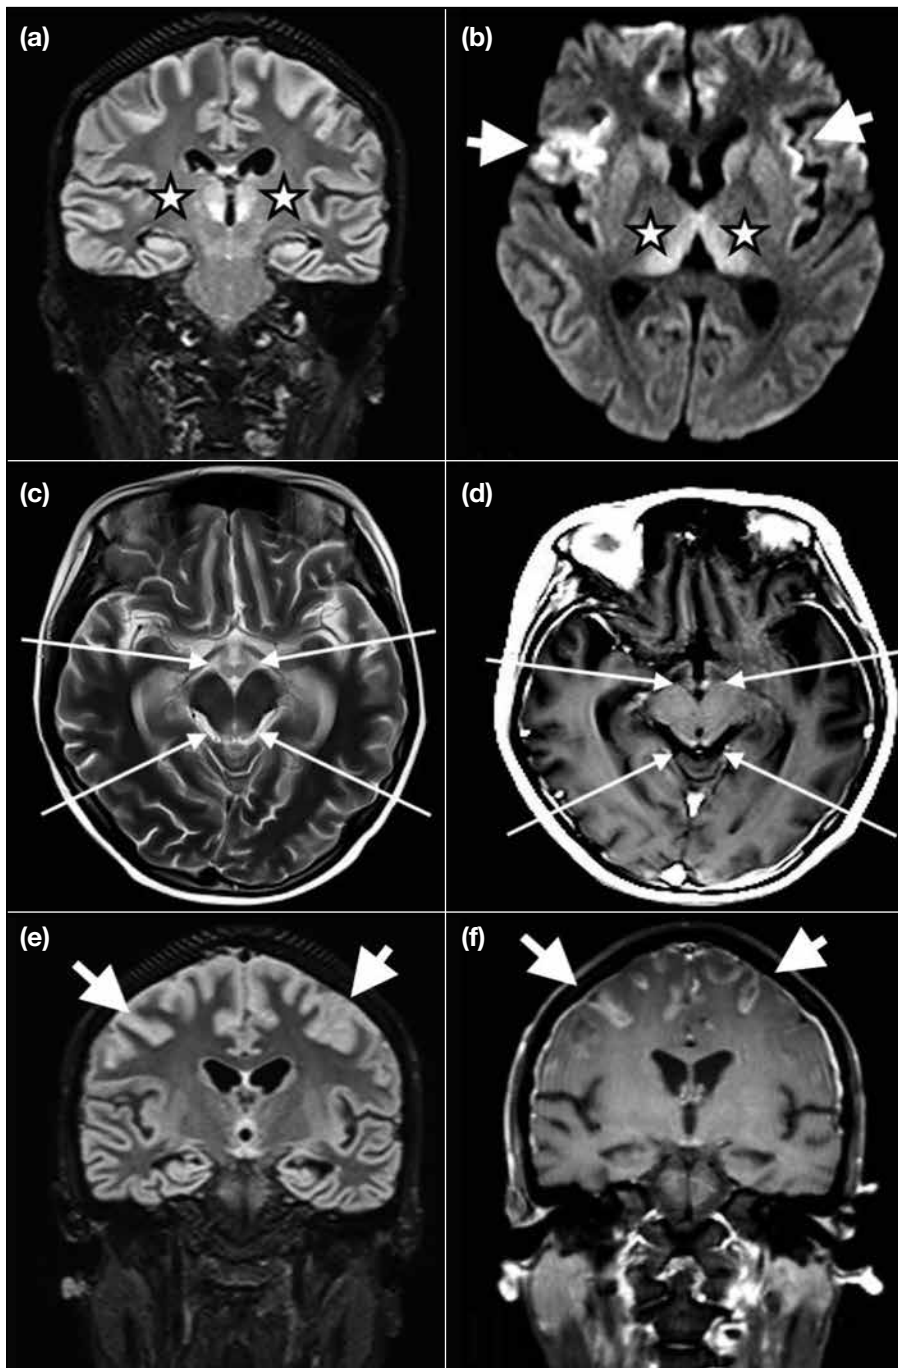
Magnetic resonance imaging of case 2. (a) Fluid-attenuated inversion recovery (FLAIR) shows symmetrical bilateral thalamic hyperintensity and (b) diffusion-weighted imaging (DWI) shows restricted diffusion in corresponding areas (stars), similar to case 1. (c) Mamillary bodies and colliculi show T2 hyperintensity and (d) contrast enhancement (long arrows). Features of cortical involvement (short arrows) imply poorer prognosis; there is (b) restricted diffusion in DWI, (e) gyral oedema in FLAIR, and (f) contrast enhancement.
